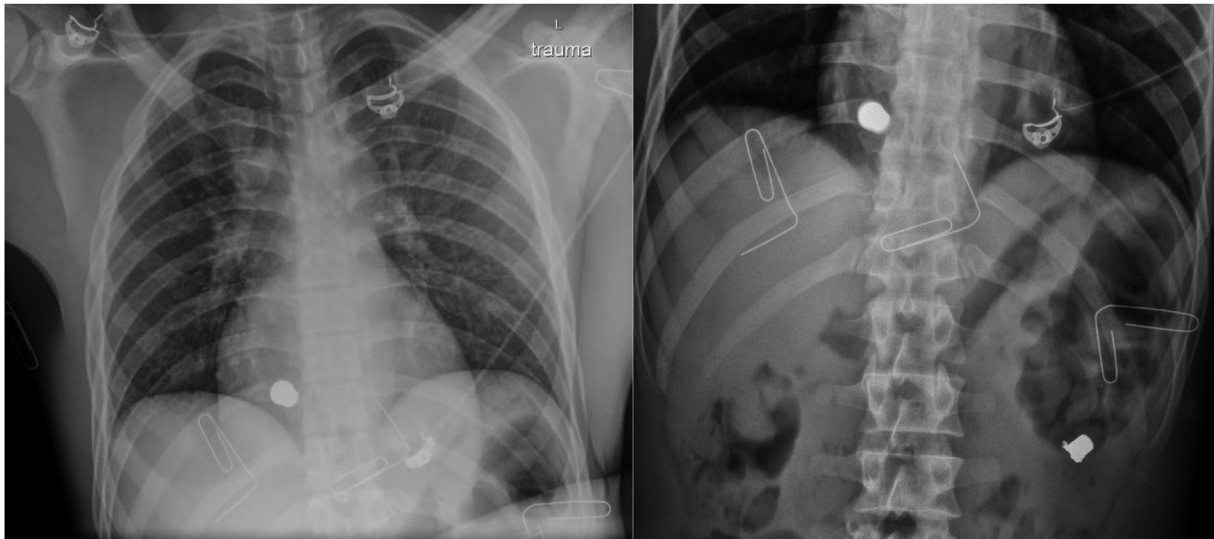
Chest and abdominal plain film radiographs at presentation. The left flank ballistic represents a bullet that was palpable in the patient's back and seemed to be associated with a left flank wound. The *paper clips* represent bullet wounds as is standard at our institution; *open paper clips* represent posterior wounds.
